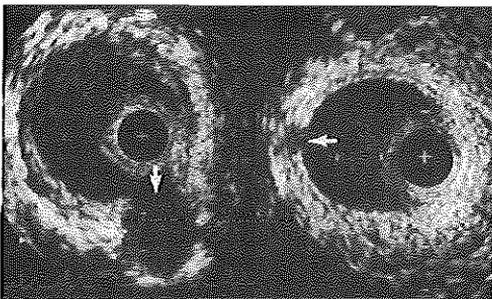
Intravascular ultrasound cross-sections of a venous bypass showing a large (left panel) and a small (right panel) side-branch (arrow). + = Catheter; calibration = 1 mm.
